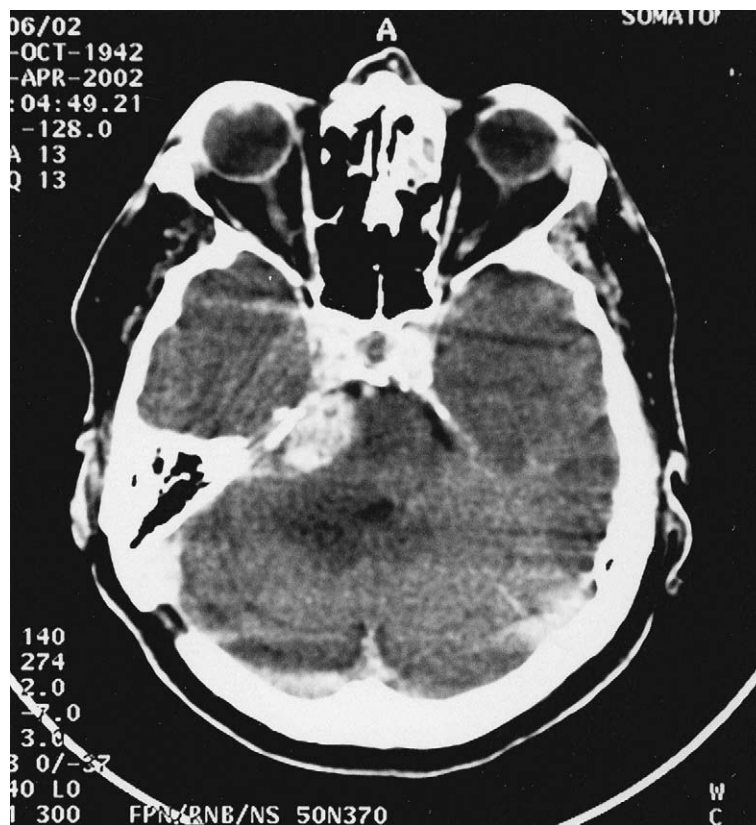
Contrast-enhanced axial CT scan. A 1.5×2 cm heterogeneously enhancing mass is seen in the right cerebellopontine angle without surrounding oedema and with a mild mass effect.
